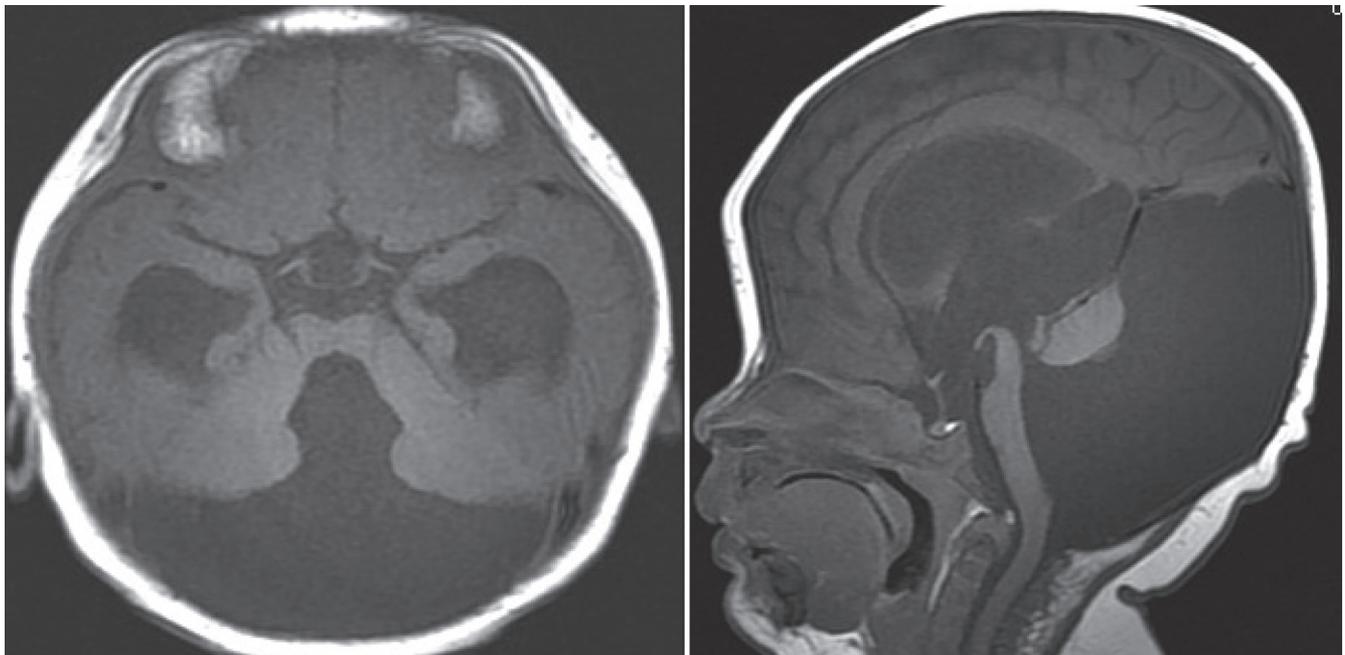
Magnetic resonance imaging (T₁) after birth shows Dandy–Walker malformation.
